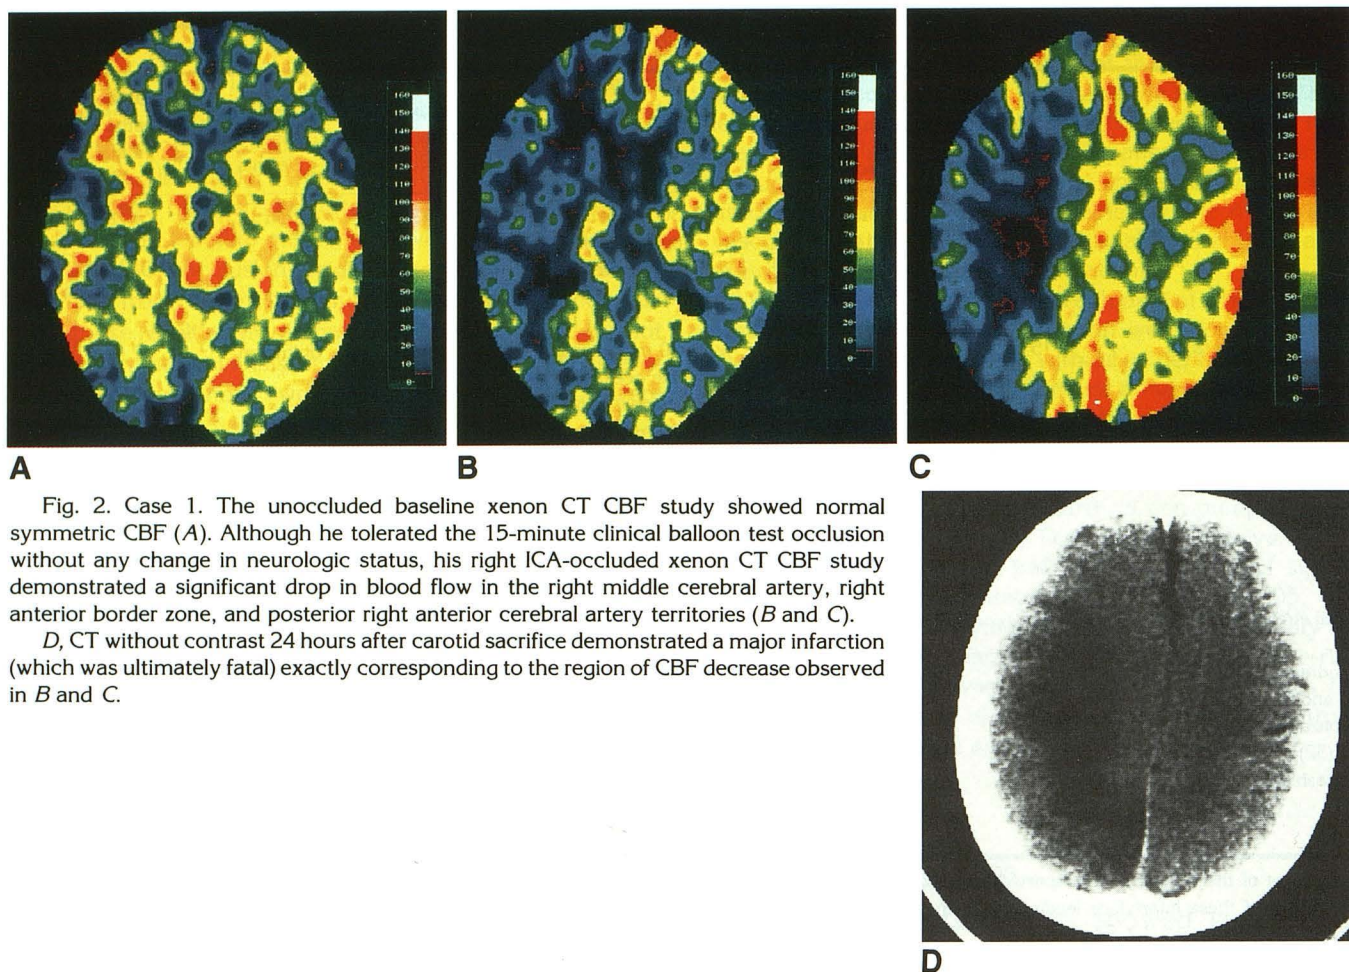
Case 1. The unoccluded baseline xenon CT CBF study showed normal symmetric CBF (A). Although he tolerated the 15-minute clinical balloon test occlusion without any change in neurologic status, his right ICA-occluded xenon CT CBF study demonstrated a significant drop in blood flow in the right middle cerebral artery, right anterior border zone, and posterior right anterior cerebral artery territories (B and C).
